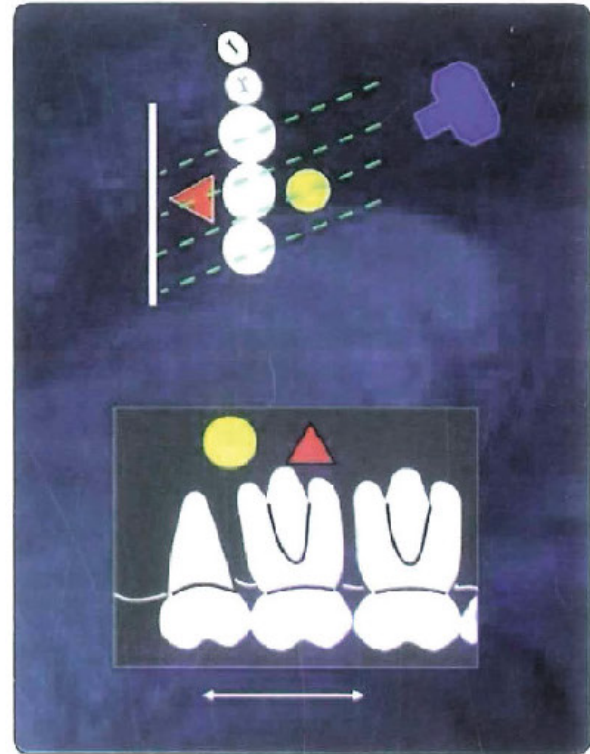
The tube-head is moved mesially and the beam is directed distally. On the radiograph the buccal object (yellow) moves distally (opposite to the tube head) in relation to the second molar and the lingual object (red) moves mesially (same direction of the tube head) in relation to the second molar.
